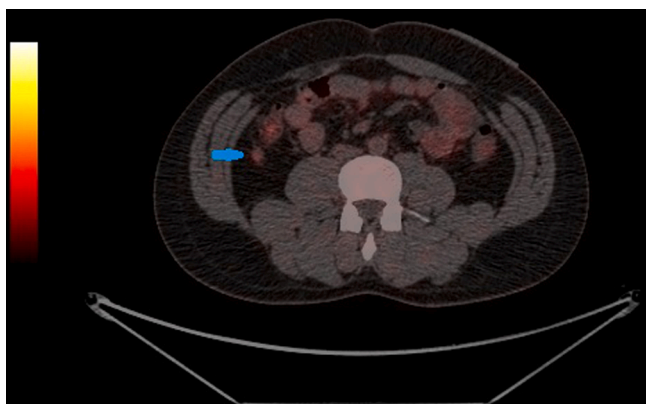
27 year old male patient with moderately differentiated adenocarcinoma with regular follow up anatomic imaging showing a indeterminate/equivocal/ suspicious mesenteric nodule and showed increased uptake on FDG PET/CT and was determined as false positive given biopsy results showing foreign body reaction likely related to glove talc.
